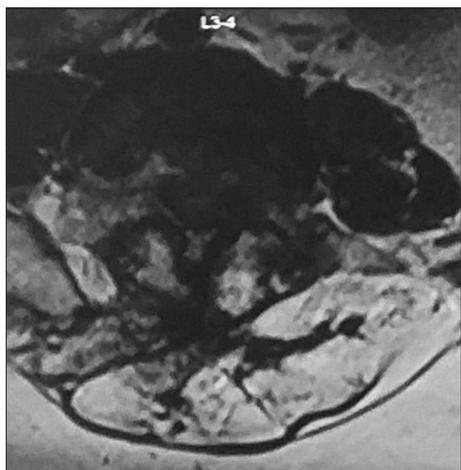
MRI scan of lumbosacral spine axial view: bilateral L3-4 foraminal narrowing and lumbar canal stenosis are seen causing bilateral L3 nerve root compression.
